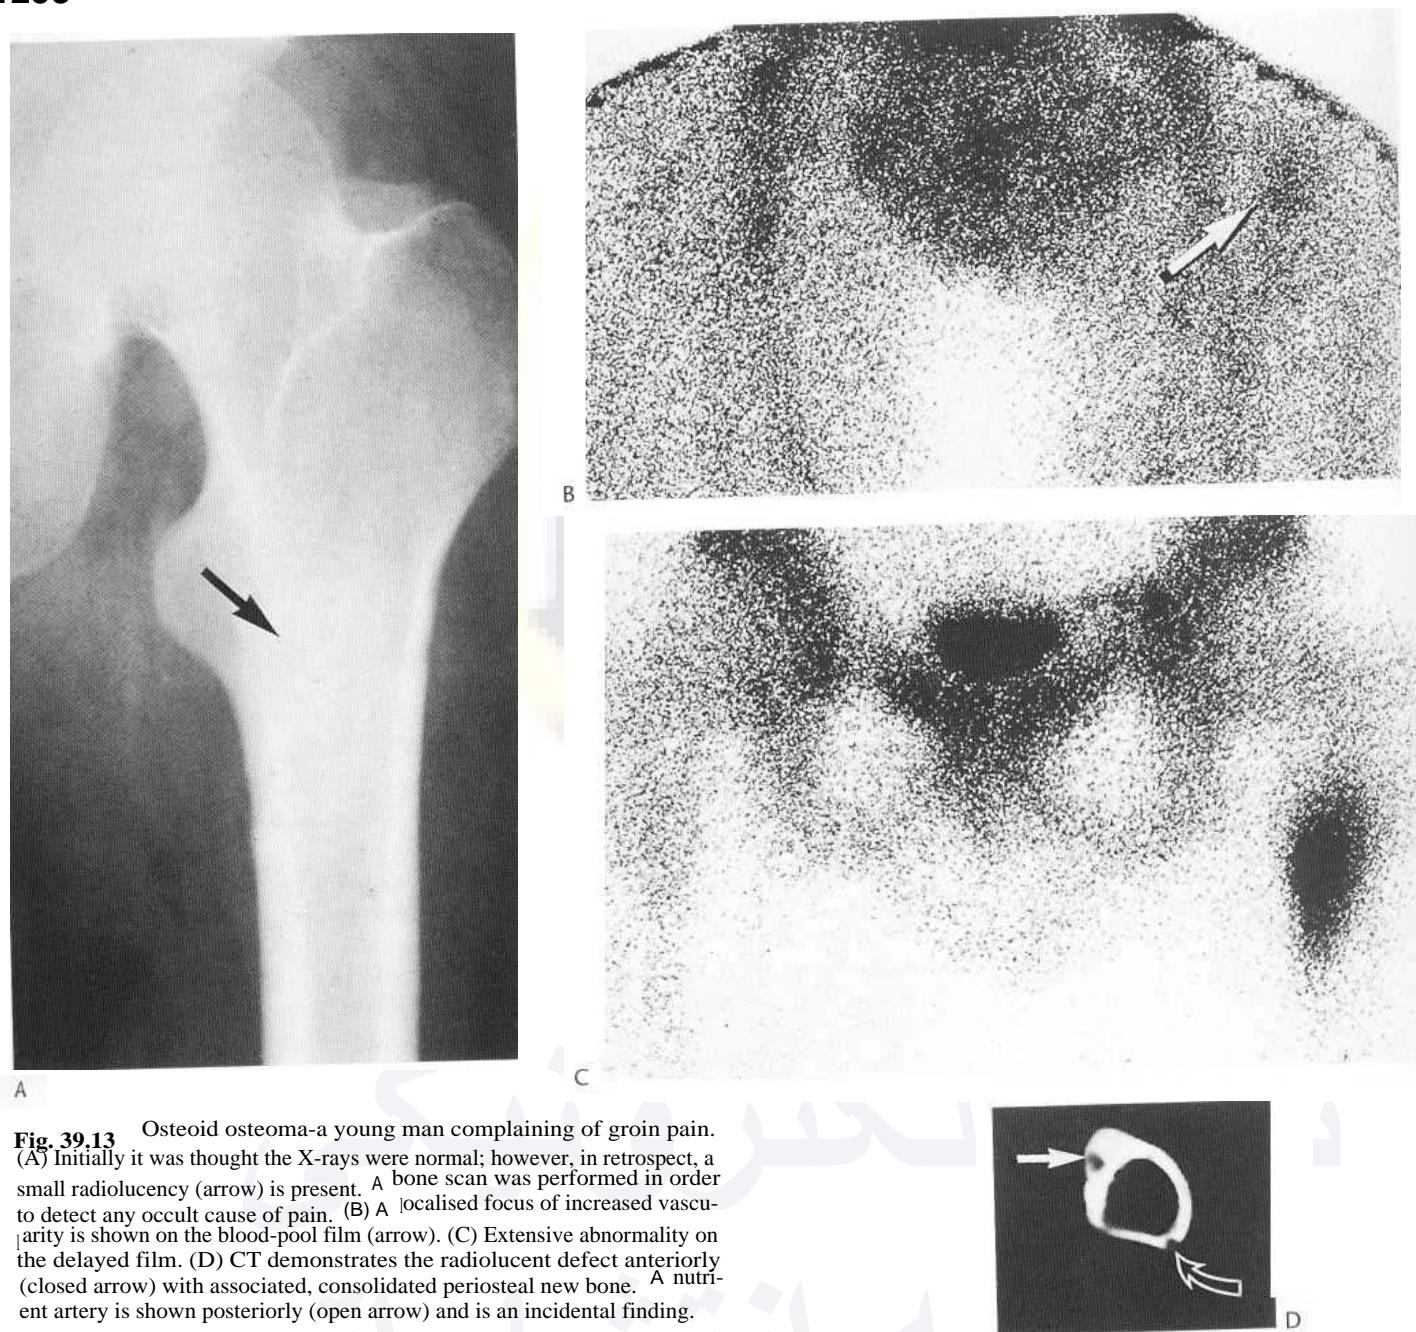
Osteoid osteoma—a young man complaining of groin pain. (A) Initially it was thought the X-rays were normal; however, in retrospect, a small radiolucency (arrow) is present. A bone scan was performed in order to detect any occult cause of pain. (B) A localised focus of increased vascularity is shown on the blood-pool film (arrow). (C) Extensive abnormality on the delayed film. (D) CT demonstrates the radiolucent defect anteriorly (closed arrow) with associated, consolidated periosteal new bone. A nutrient artery is shown posteriorly (open arrow) and is an incidental finding.
